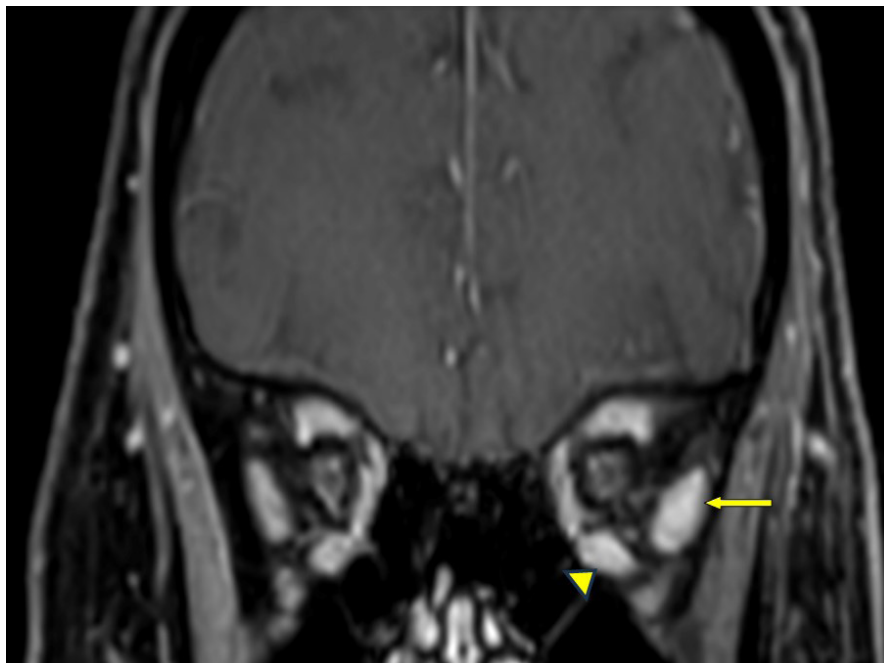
MRI T1 fat saturated post contrast coronal image of both orbits shows thickening and enhancement of the lateral rectus (arrow) and inferior rectus (arrow head) on left side.
